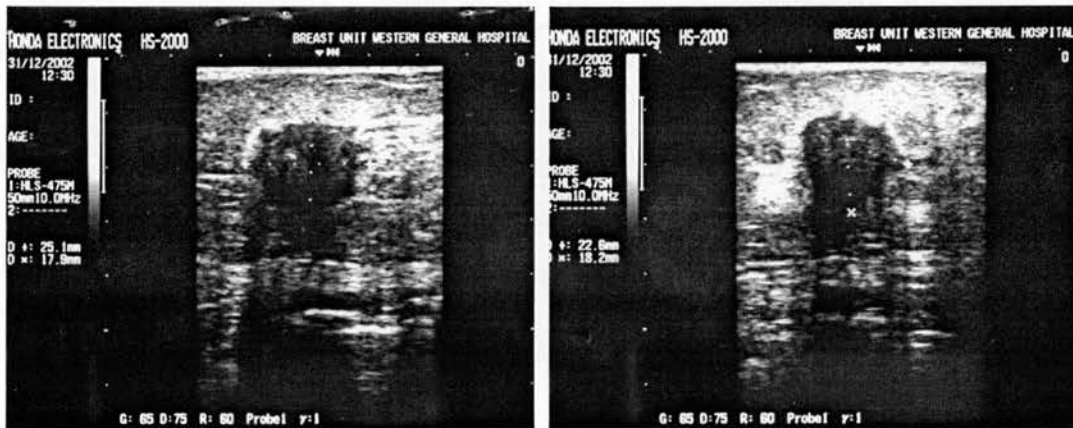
Measurements being taken of tumour on ultrasound scan
